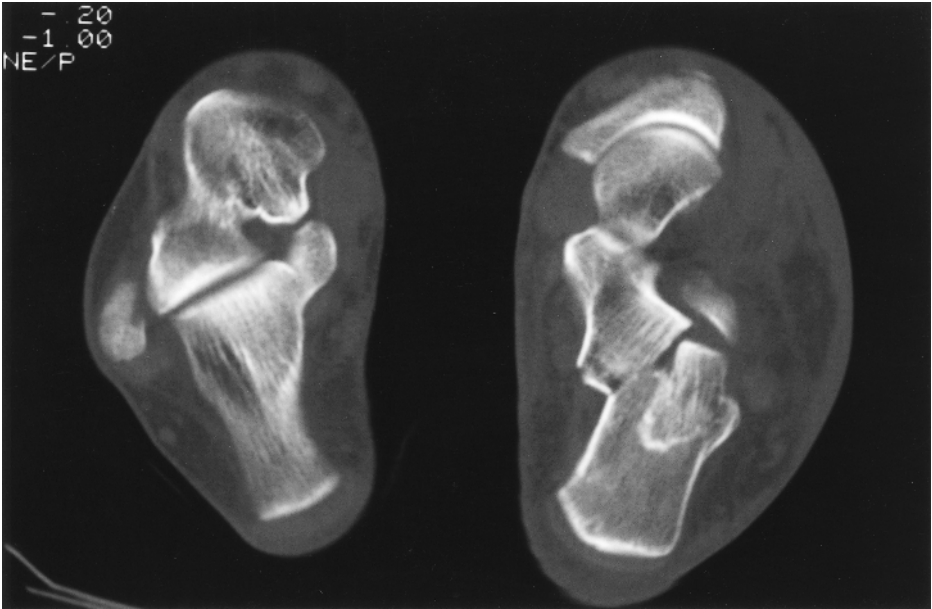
Comminuted calcaneal fracture of the left foot is best demonstrated on this axial CT scan.
